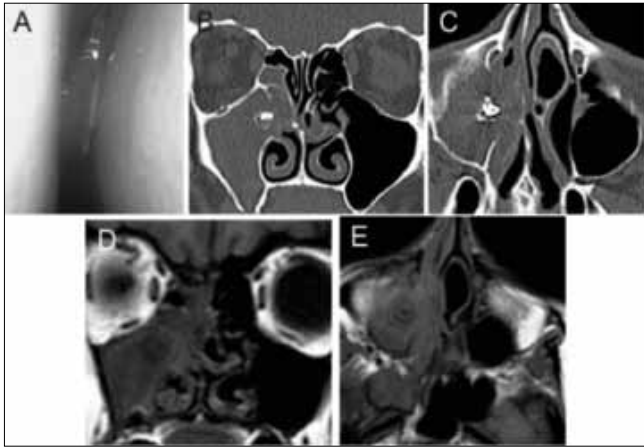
Patient 21. SCDĐT resulting from dental treatment complicated by fungal ball sinusitis (Class 3b). A) Preoperative endoscopic view of purulent secretions in the right middle meatus; B, C) Coronal and axial maxillofacial CT scans showing radiodense material and erosion of bone in the right maxillary sinus indicative of aspergillosis with obstruction of the ostiomeatal complex; D, E) Coronal and axial T1 magnetic resonance image in the same patient showing iso- or hypointensity on T1-weighted images in the right maxillary sinus.
